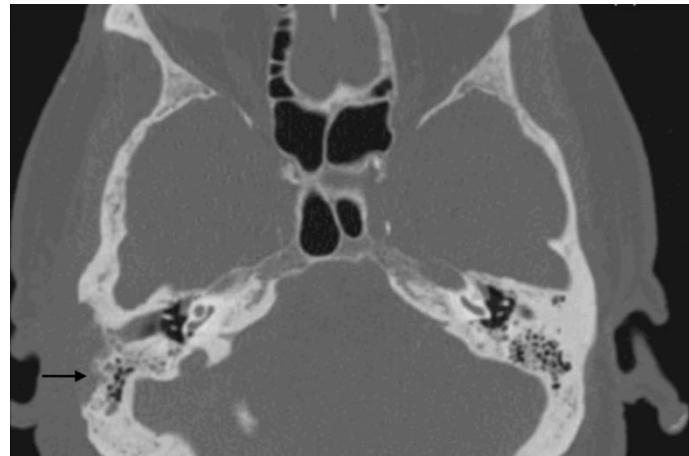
Axial CT scan of the temporal bone. Erosion of the cortical temporal bone (arrow) with an inflammatory process extending to the mastoid without involvement of the middle ear
